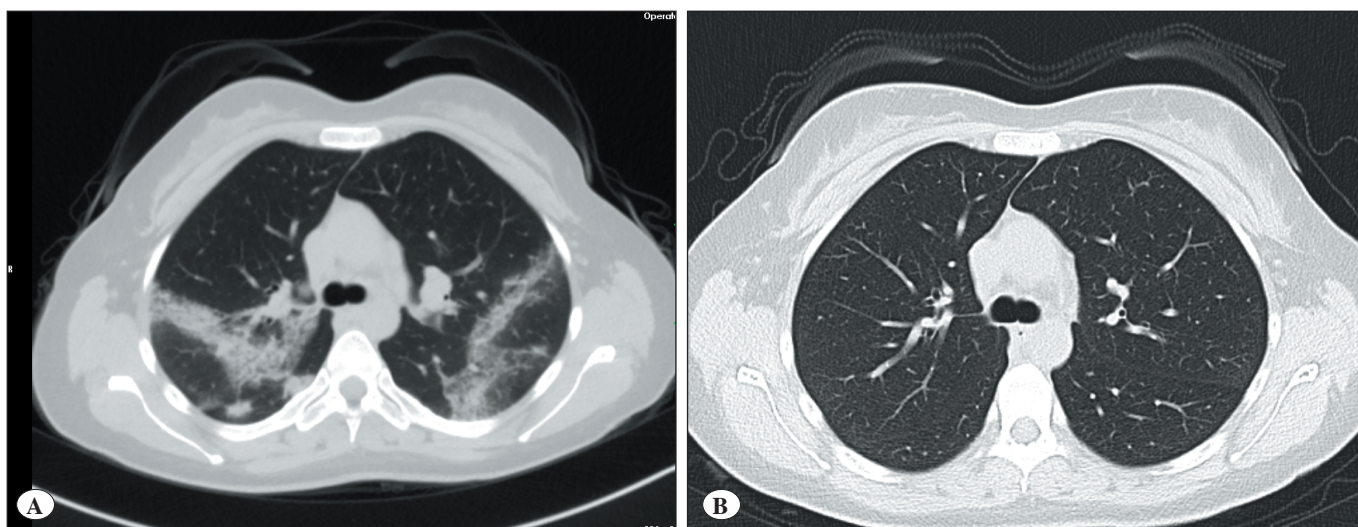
A) Pre-treatment high-resolution computed tomography (HRCT) image showing peripheral and upper-lobe-predominant consolidations with ground-glass opacities. B) Follow-up high-resolution computed tomography (HRCT) image obtained at 1 month after benralizumab, demonstrating marked regression of the previously observed consolidations and ground-glass opacities, with minimal residual subpleural changes.
